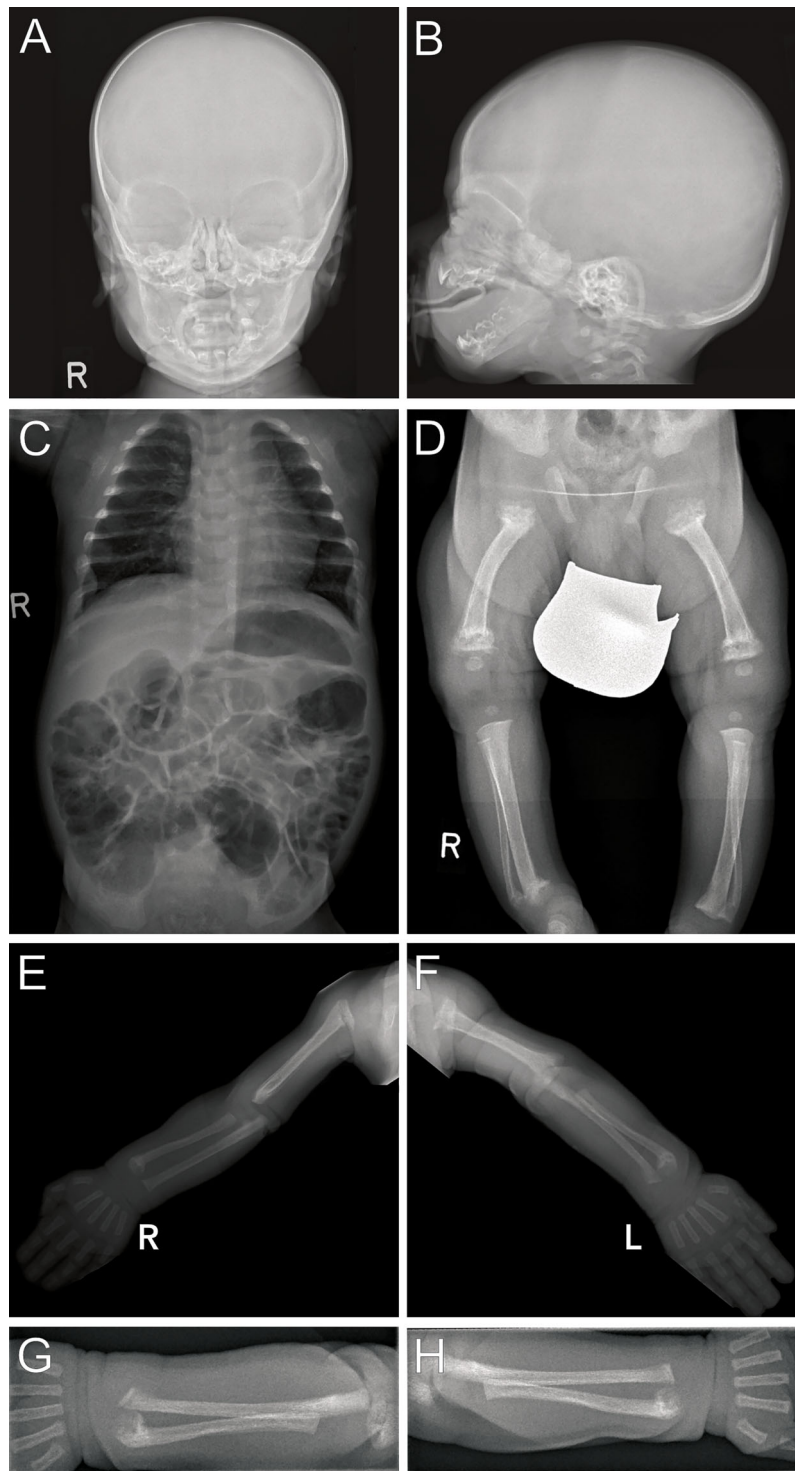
Radiographs (Patient 2) at 3 weeks of life: Images of the skull (A, B) show blurred borders at the cortical/medullary bones and wide sutures with occipital intrasutural bones (Wormian bones). Poor mineralization is present in the skeleton as seen on the thoracoabdominal radiograph (C) arms and legs. Multiple metaphyseal fractures are present in both arms, with malalignments of the radius and ulna (E–H). Distal fractures of the right tibia and fibula are present (D), with internally rotated position and, to a lesser extent, likewise on the left. Fractures on the left side are close to consolidation, indicating intra uterine onset of fractures.
